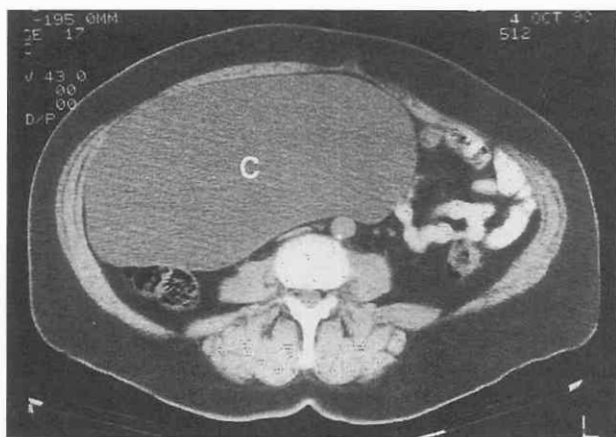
Mucinous cystadenoma of the ovary. CT scan through the purely cystic abdominal mass (C) in an asymptomatic 66-year-old woman with a palpable mass.
